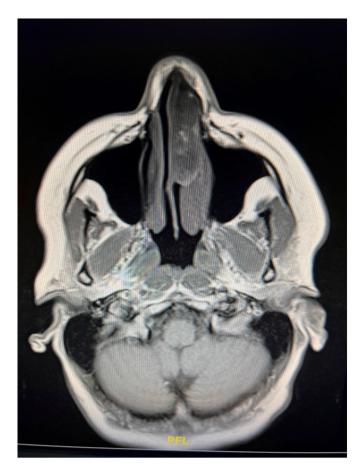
MRI T1 revealed a hypointense lesion on the non-contrast T1 image.
